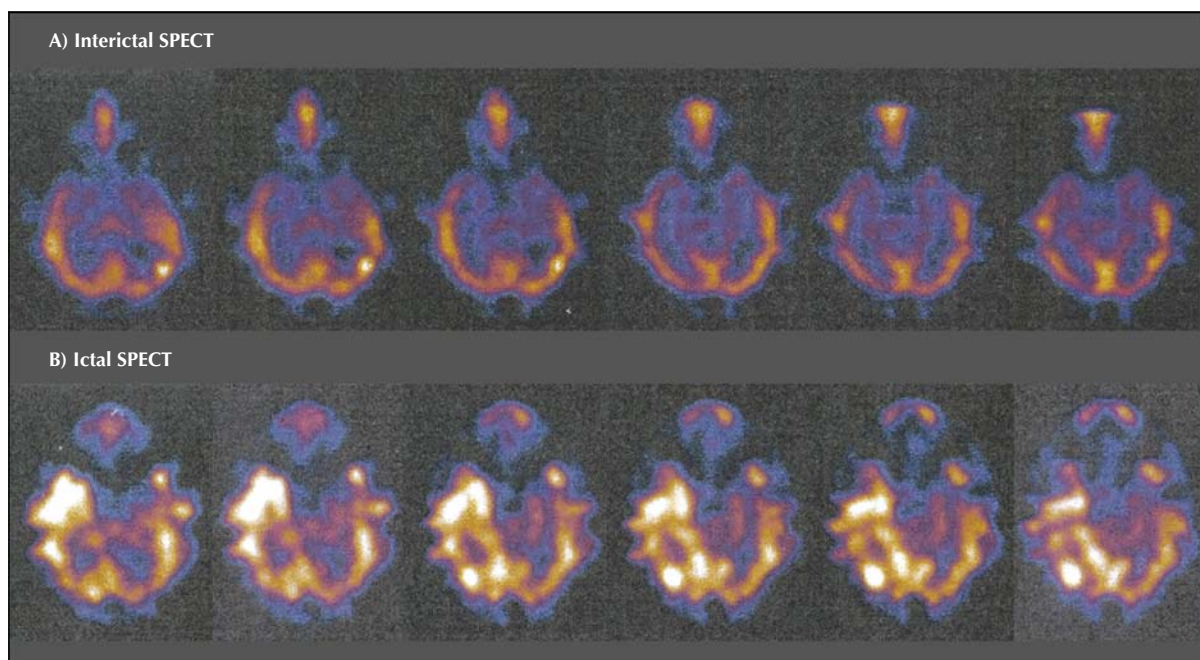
Patient 1 was injected for an ictal SPECT 10 s prior to the ictal propagation to the occipital lobe. In comparison to the interictal SPECT (A), the ictal SPECT (B) showed a tracer enhancement in the temporal as well as the occipital cortex.
